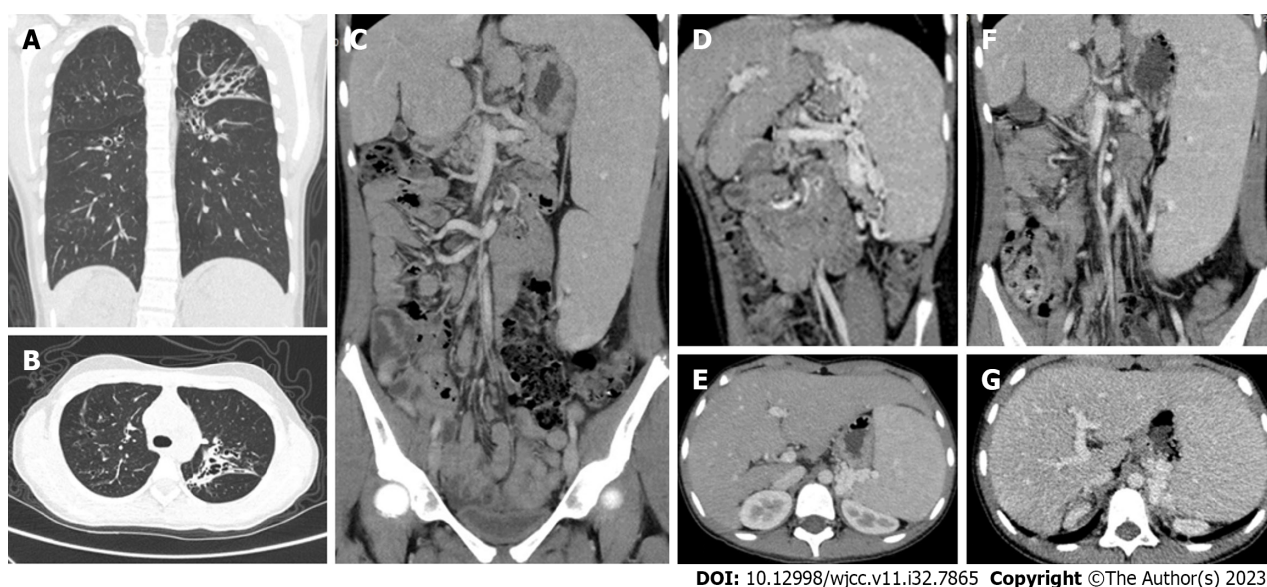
Chest and abdominal computed tomography. A and B: Chest computed tomography (CT) showed bronchial dilatation and flocculent shadow with multiple cystic translucency in both lungs; C-E: Preoperative whole abdominal enhanced CT showed splenomegaly, multiple tortuous dilated vessels at the splenic hilum, irregular liver morphology and pancreatic atrophy; F and G: 17-month postoperative whole abdomen enhanced CT showed irregular liver morphology, splenomegaly, multiple tortuous dilated vessels at the splenic hilum, and pancreatic atrophy.
